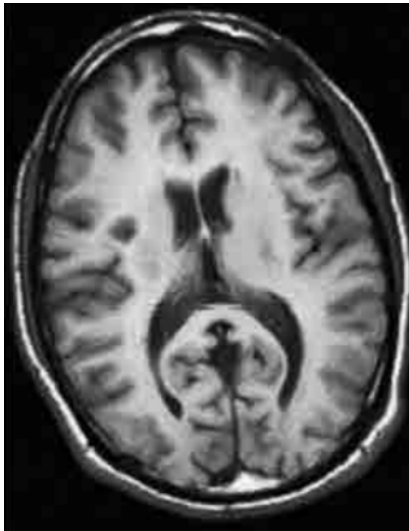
T1-weighted image from an axial view. Bright areas of the brain indicate WM and dark areas represent grey matter.
